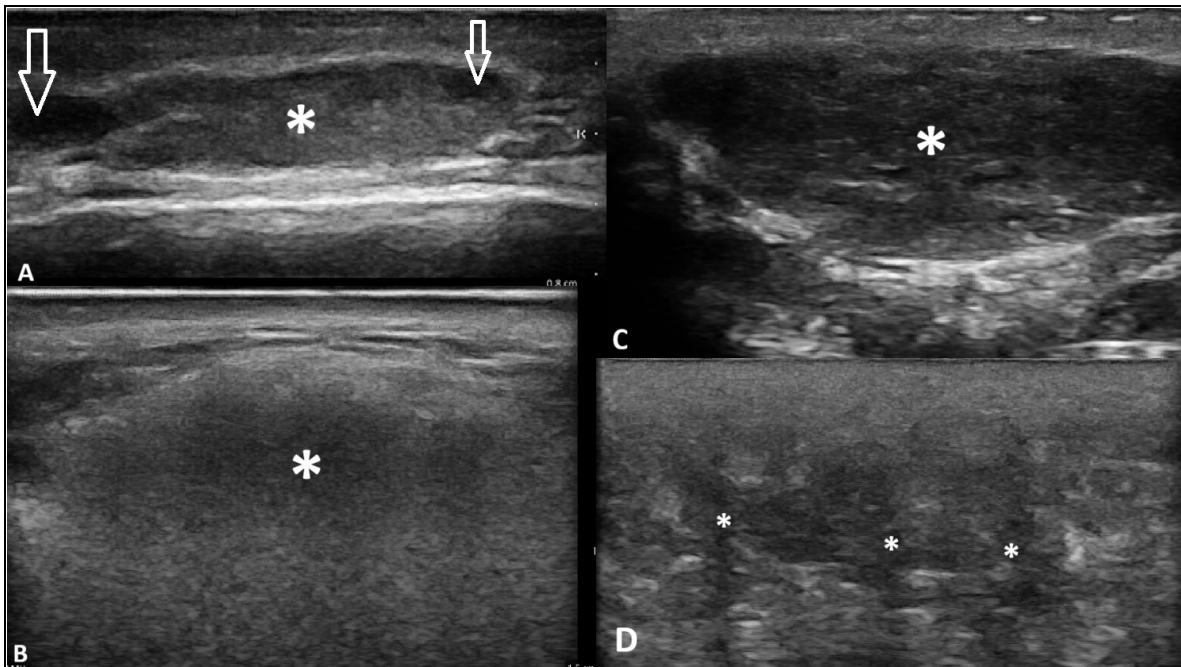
Representative ultrasonographic images of filler-related complications (A) Ultrasound image obtained 12 months after hyaluronic acid injection to the glabellar region, demonstrating a nodular granulomatous lesion with a central hyperechoic component (asterisk) and surrounding hypoechoic to anechoic foci corresponding to residual hyaluronic acid deposits (arrows). (B) Ultrasound image of silicone filler in the zygomatic region showing a hypoechoic nodular lesion (asterisk) with a characteristic “snowstorm” pattern, consistent with silicone. (C) Ultrasound image acquired 11 years after mid-face hyaluronic acid injection, demonstrating a heterogeneous hypoechoic lesion (asterisk) compatible with abscess formation. (D) Ultrasound image obtained five months after calcium hydroxylapatite (CaHA) injection to the zygomatic region, demonstrating diffuse edema and inflammatory changes with characteristic hypoechoic acoustic shadowing(asterisk) columns secondary to calcium deposits.
